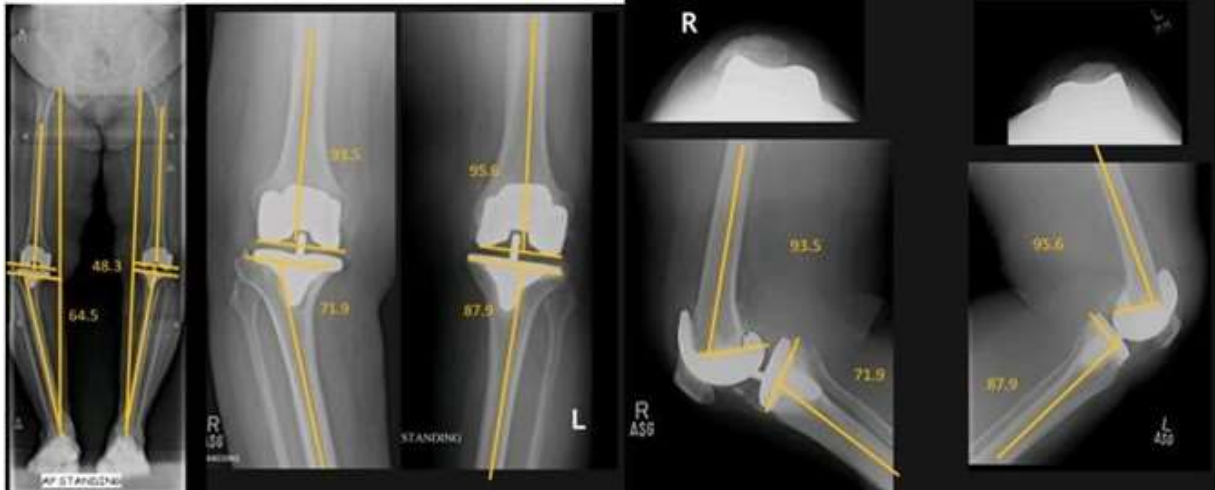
Radiographs from a 50-year-old patient's bilateral TKA eight years ago, which reveal osteolysis and a misaligned prosthesis.
